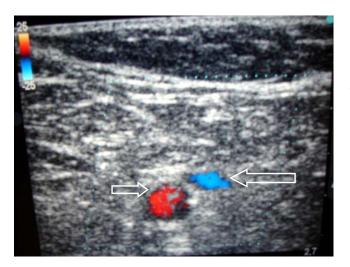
Using color Doppler to identify the vessel, short arrow artery, long arrow vein.
